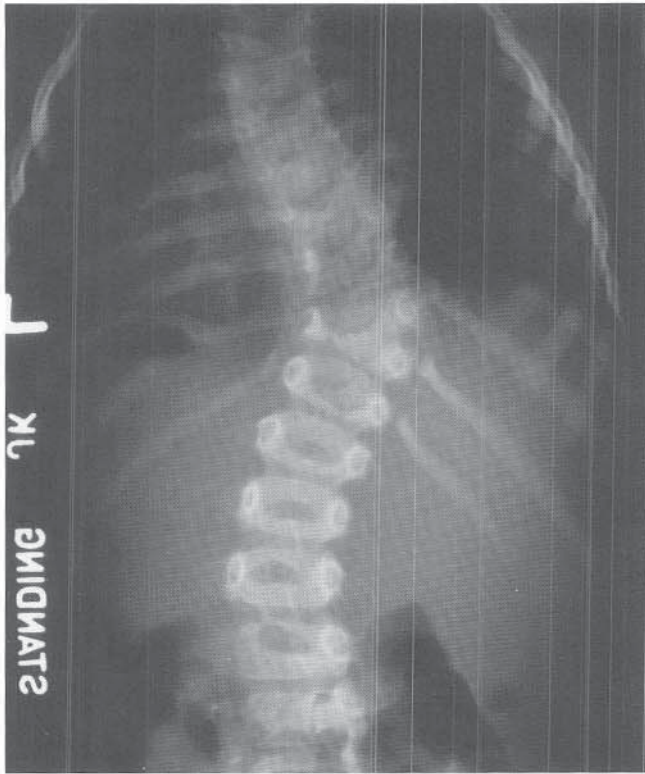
Spine radiograph of a 2-year-old girl with a 53-degree congenital scoliosis and semisegmented hemivertebrae at levels T8 and T10. A rib accompanies each of these hemivertebrae. This deformity is partially balanced by a left-sided hemivertebra at the T4 level. The deformity slowly progressed to 61 degrees by 9 years of age, at which time she underwent fusion.
